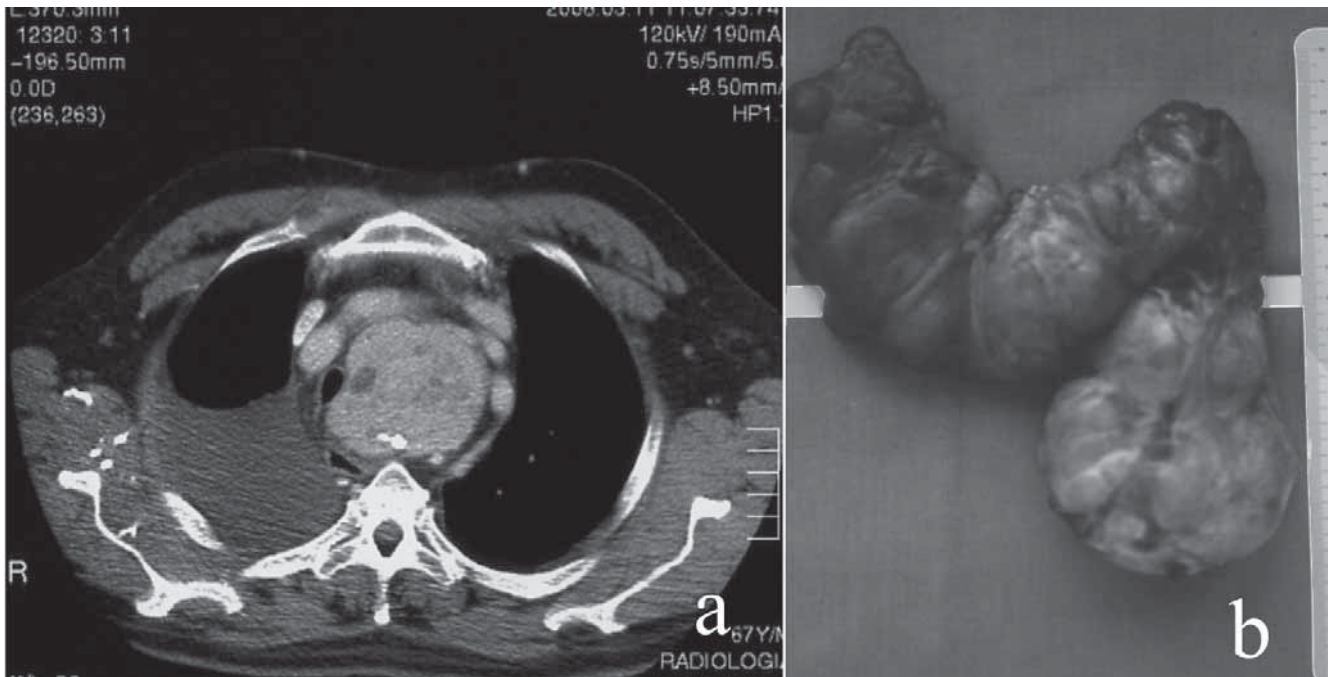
a. Axial CT showing large mass of RG causing compression of trachea and oesophagus. b. RG of the same patient following surgery (weight of thyroid: 540 g).
